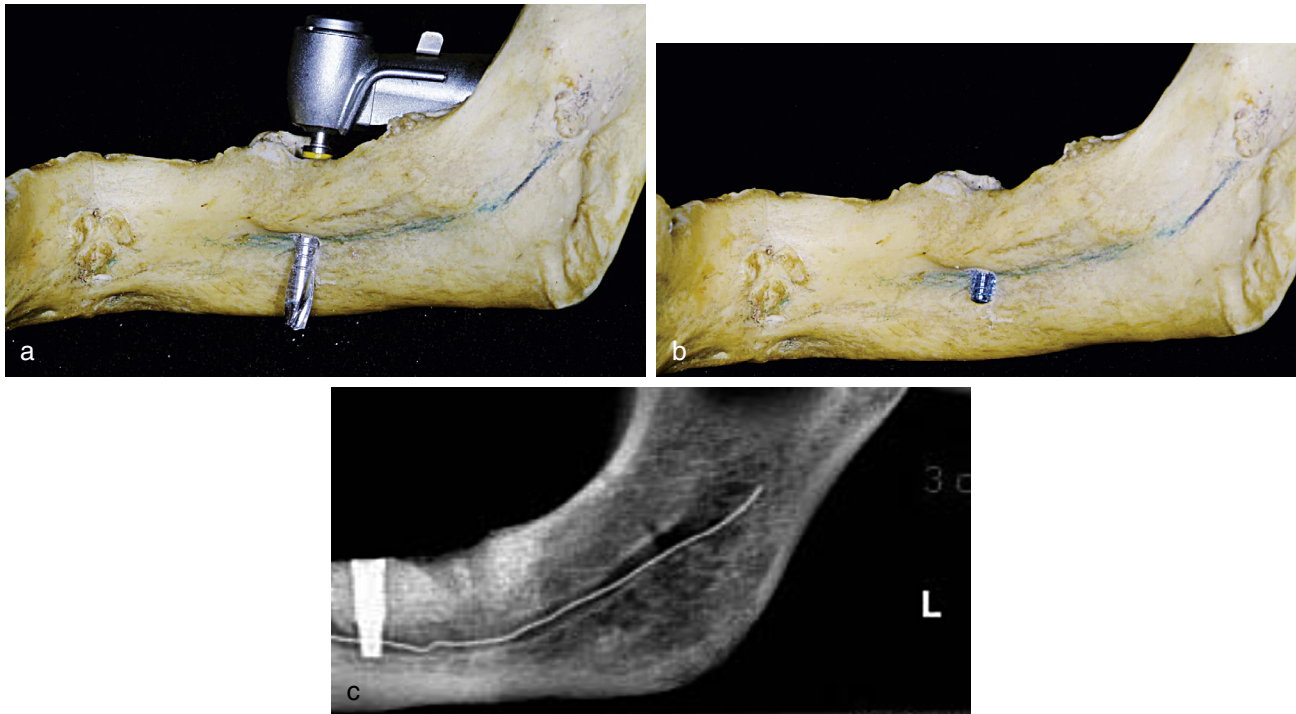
(a) Medial surface of the mandible showing operator's error when the drill is accidentally excessively inclined lingually. (b) This involves first a perforation of the sublingual lodge with the consequent damage of structures contained in it. If the drill goes beyond the mylohyoid muscle, inserted onto the mylohyoid line, marked in *blue*, it will get to the suprahyoid region and the submandibular lodge. (c) The two-dimensional view of the orthopantomogram does not allow appreciation of the serious mistake committed during the surgery. In the first and second molar sites the lingual cortical bone perforation can injure the mylohyoid artery, running in the homonymous groove.
